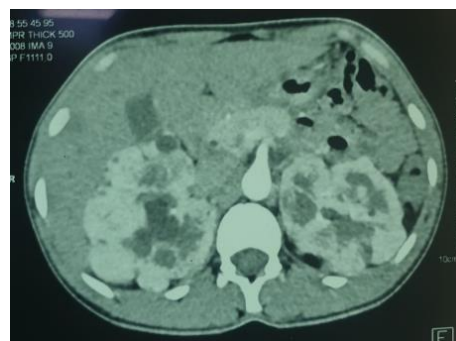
Axial contrast-enhanced CT scan showing bilateral solid-cystic renal mass.
